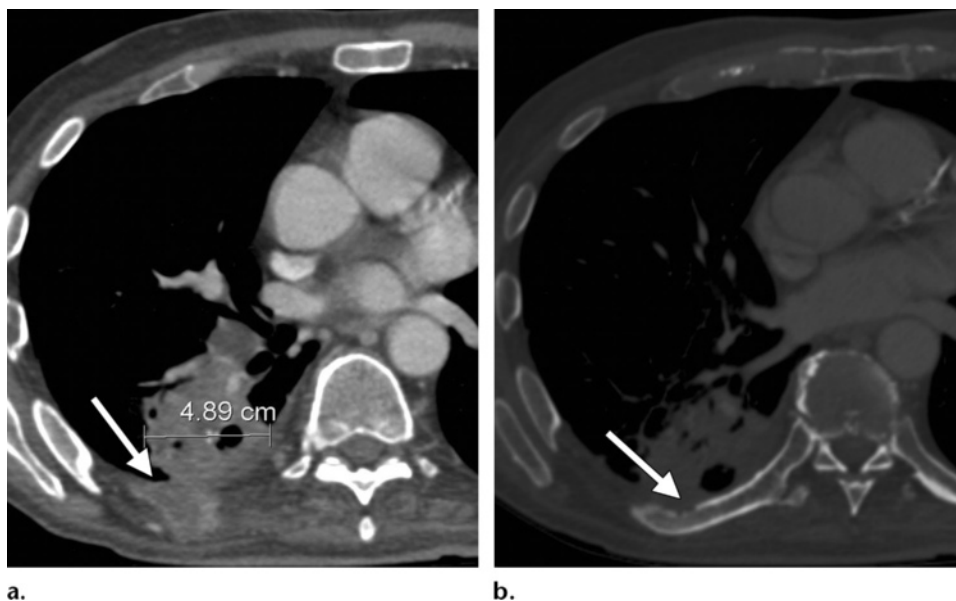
Chest wall and pleural invasion. Chest CT scans obtained with a soft-tissue window (a) and a bone window (b) show a right upper lobe mass measuring 4.9 cm in diameter, with a chest wall mass (arrow in a) and associated bone destruction of the adjacent posterior rib (arrow in b). These findings are definitive for chest wall invasion.
